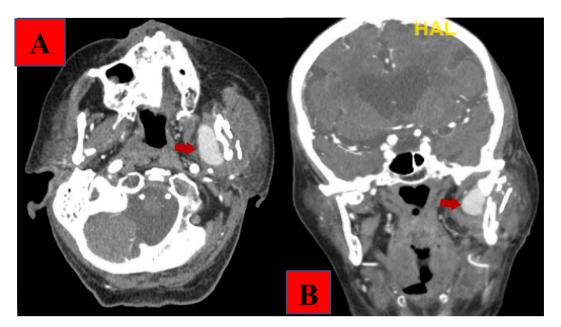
Head and Neck CTA after 2nd operative intervention. (A) Axial image demonstrates a pseudoaneurysm medial to left mandibular fracture. (B) Coronal image shows the pseudoaneurysm off of the left internal maxillary artery.
